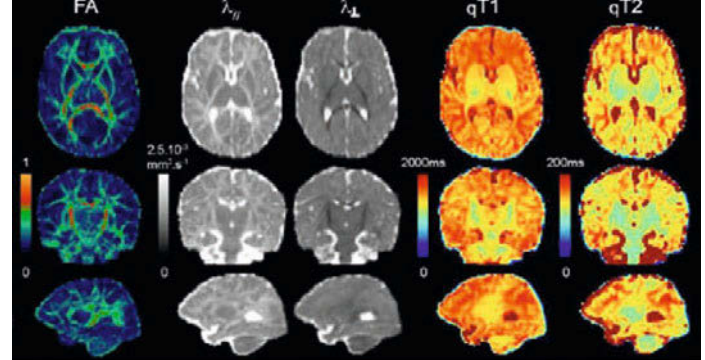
Quantitative maps of the MRI parameters in a 6-week-old infant
